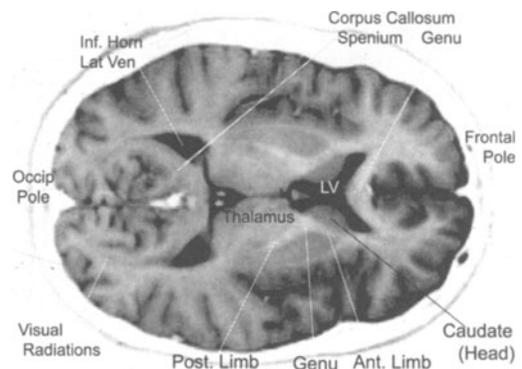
Horizontal section, demonstrating the anterior limb, genu, and posterior limb of the internal capsule. Note the putamen and globus pallidus are external to the internal capsule. (MRI weighted T2.)
